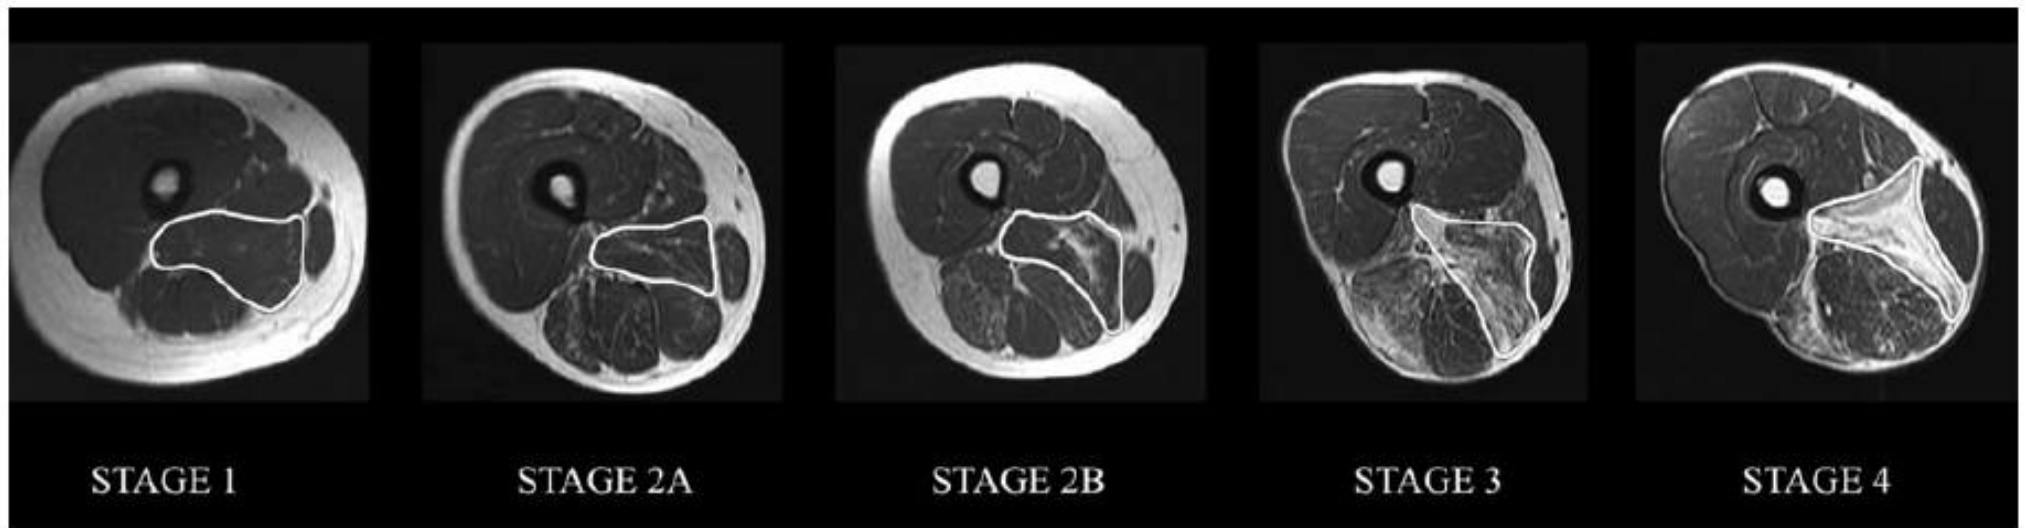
Axial T1-weighted images of the thigh showing fatty infiltration according to the Mercuri scale.
